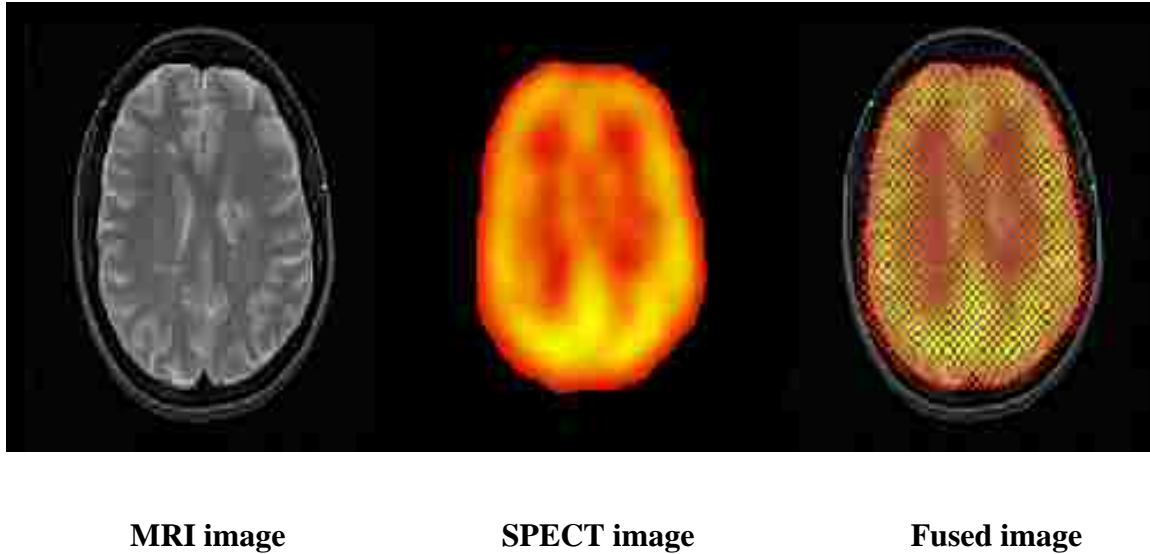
Example of a Brain Image Registration of MRI with SPECT [24]
